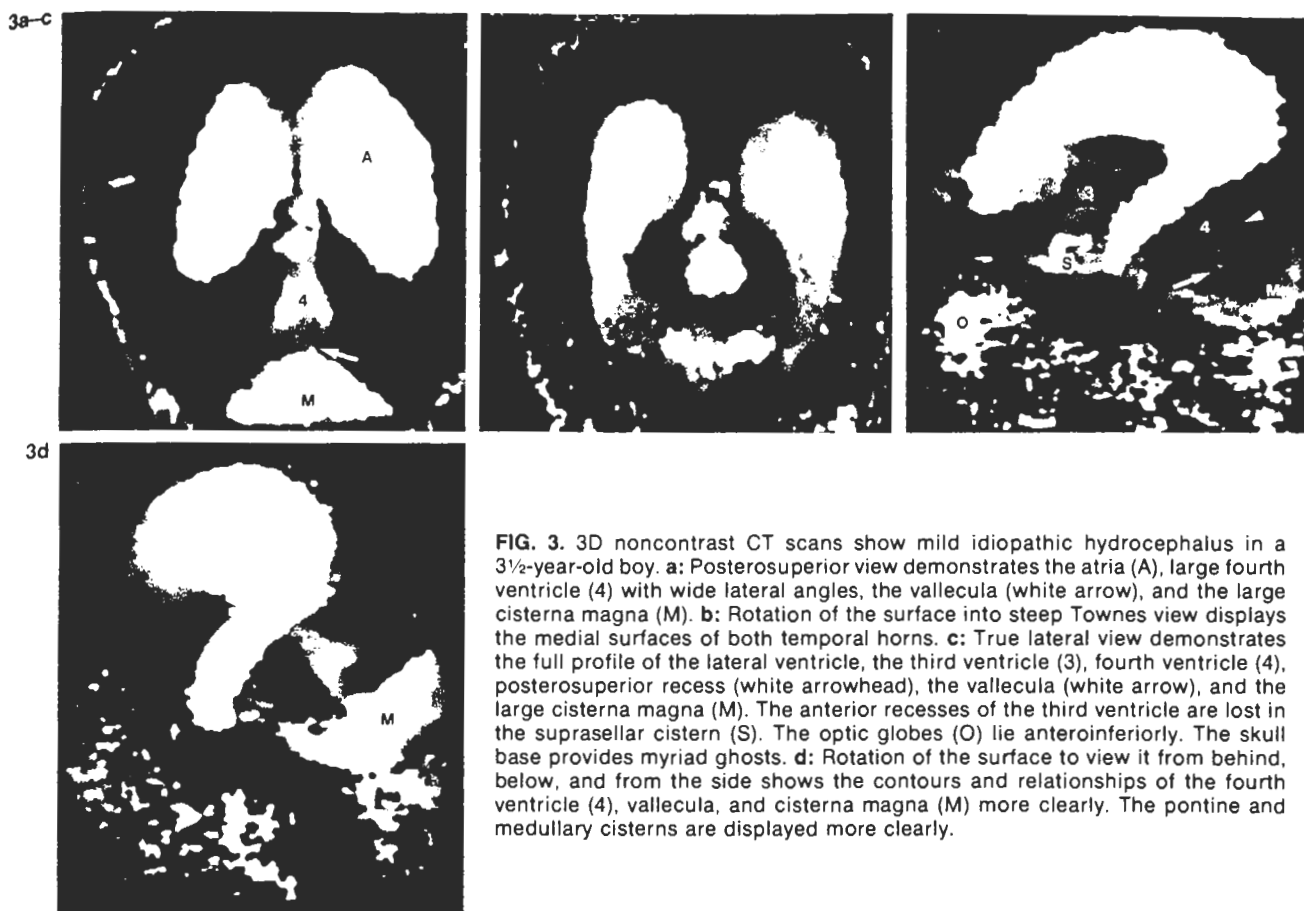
3D noncontrast CT scans show mild idiopathic hydrocephalus in a 3½-year-old boy. a: Posterosuperior view demonstrates the atria (A), large fourth ventricle (4) with wide lateral angles, the vallecule (white arrow), and the large cisterna magna (M). b: Rotation of the surface into steep Townes view displays the medial surfaces of both temporal horns. c: True lateral view demonstrates the full profile of the lateral ventricle, the third ventricle (3), fourth ventricle (4), posterosuperior recess (white arrowhead), the vallecule (white arrow), and the large cisterna magna (M). The anterior recesses of the third ventricle are lost in the suprasellar cistern (S). The optic globes (O) lie anteroinferiorly. The skull base provides myriad ghosts. d: Rotation of the surface to view it from behind, below, and from the side shows the contours and relationships of the fourth ventricle (4), vallecule, and cisterna magna (M) more clearly. The pontine and medullary cisterns are displayed more clearly.
